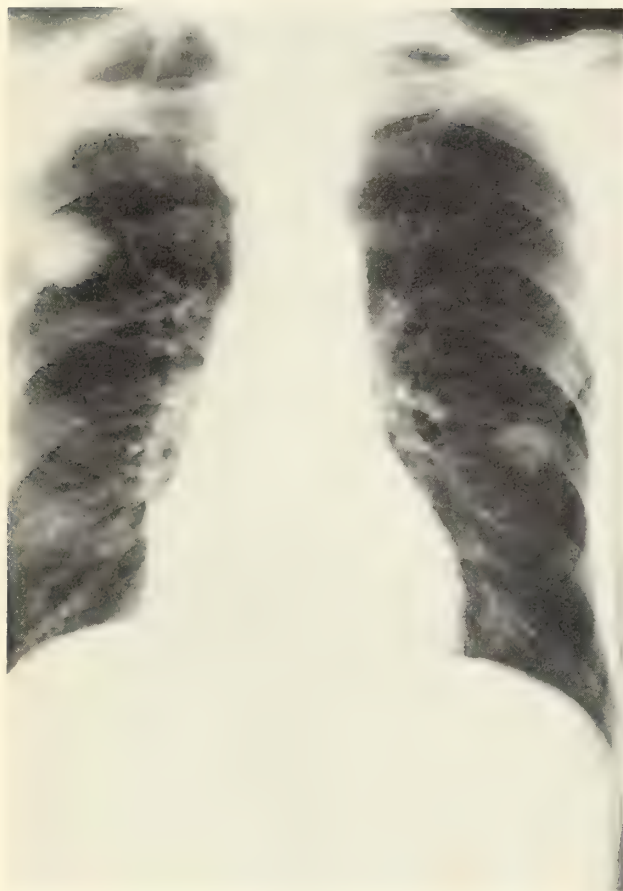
PA chest radiograph demonstrating bilateral pulmonary nodules.
